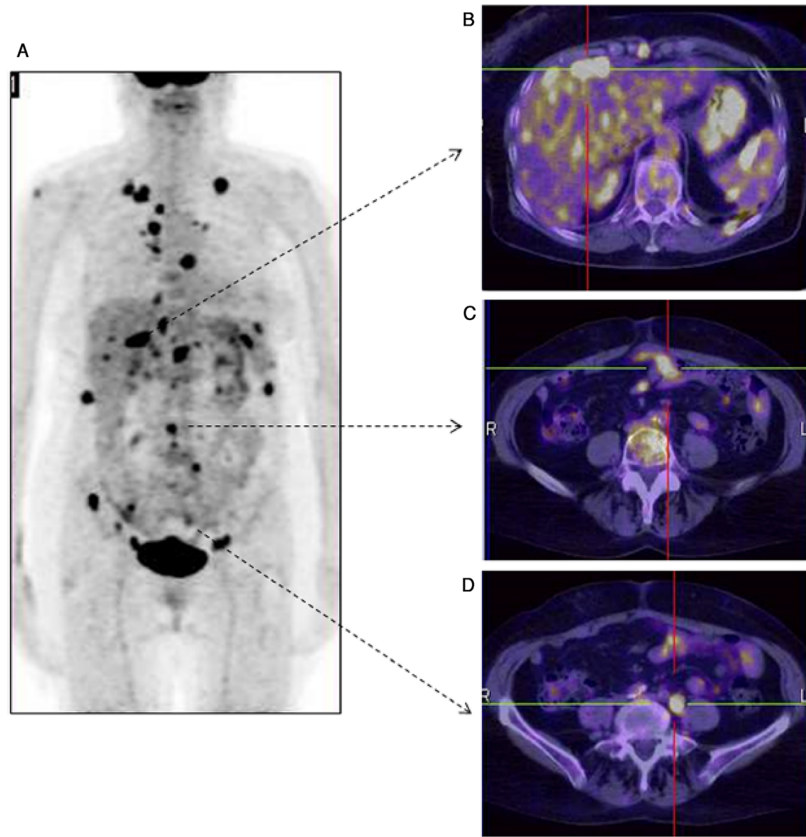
FDG-PET/CT of recurrent ovarian cancer.
